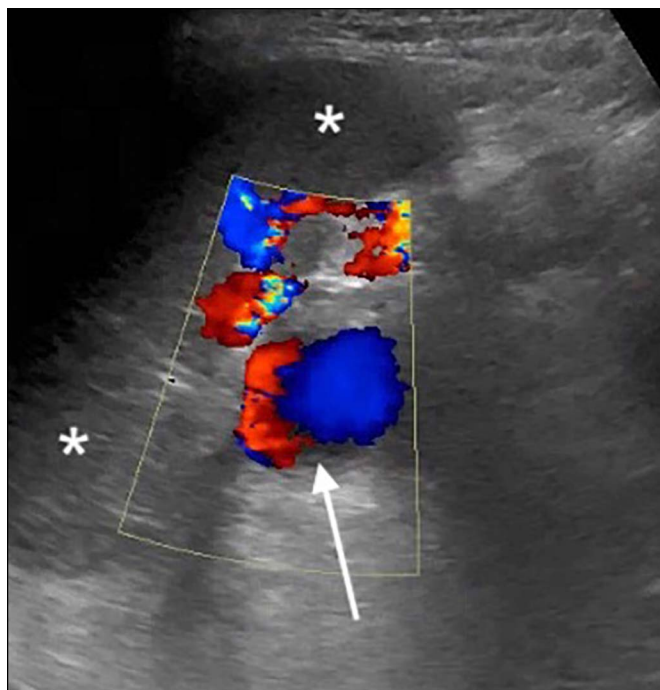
Color Doppler ultrasound of the spleen (white asterisks) demonstrates a large pseudoaneurysm with the splenic hilum (white arrow).
